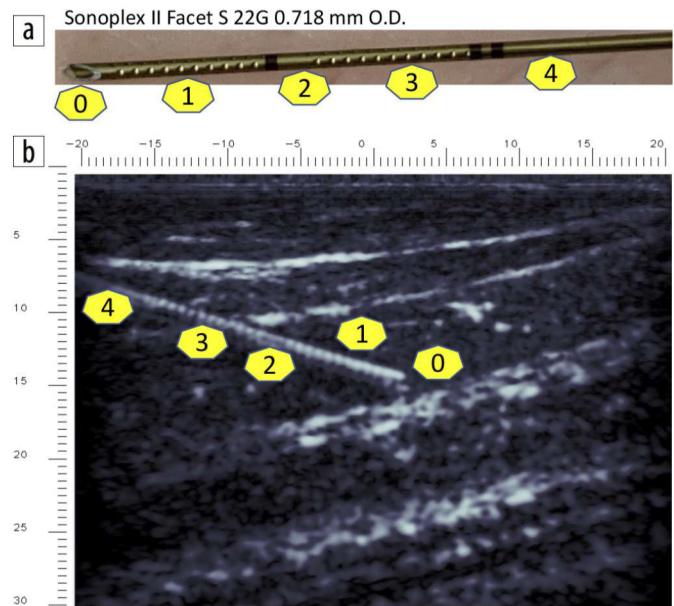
An ultrasound-guided intervention experiment. (b) The needle and fatty tissues are hyperechogenic (white colors) and muscular tissues are hypoechogenic (dark colors). The number signs on the image match those on (a) the needle.
